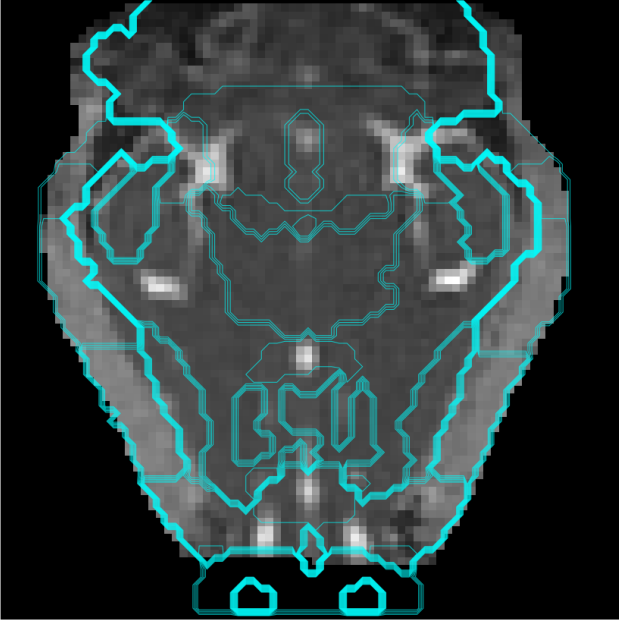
Representative quality control image showing the accurate co-registration of the brain atlas (turquoise outlines) with a b0-weighted MR image of an Egyptian fruit bat brain. This visual confirmation of precise anatomical alignment ensures the integrity of extracted regional brain morphometric features.
